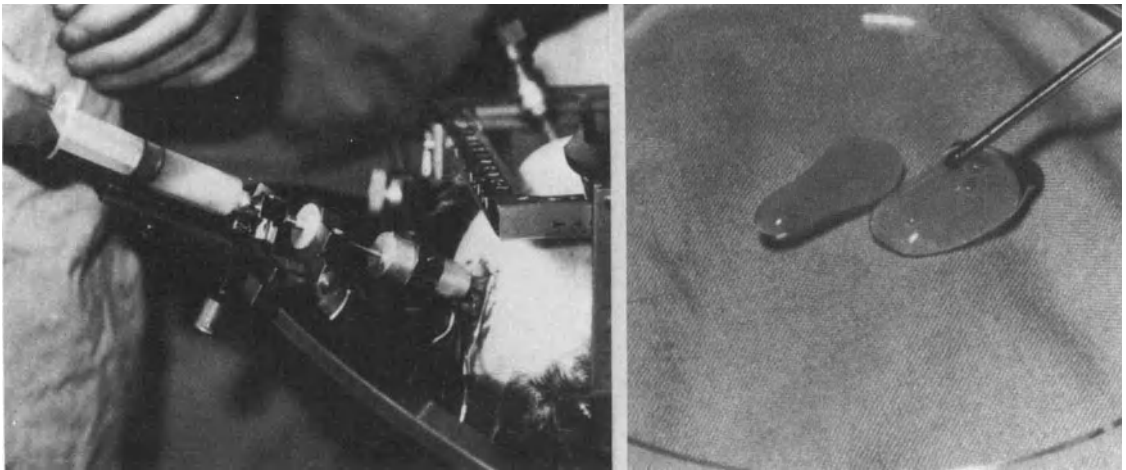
(*Left*) Intraoperative aspiration of colloid cyst. All patients were awake. The probe guide attaches to the frame and permits low artifact CT imaging. (*Right*) Evacuation of viscous colloid material. If the material is of greater viscosity (cheese-like), aspiration is impossible.
